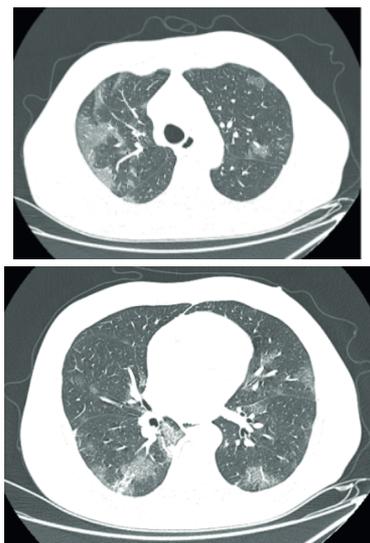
Chest computed tomography (04/21/21 - 11:08 pm). Multiple ground-glass pulmonary opacities, predominantly peripheral.
